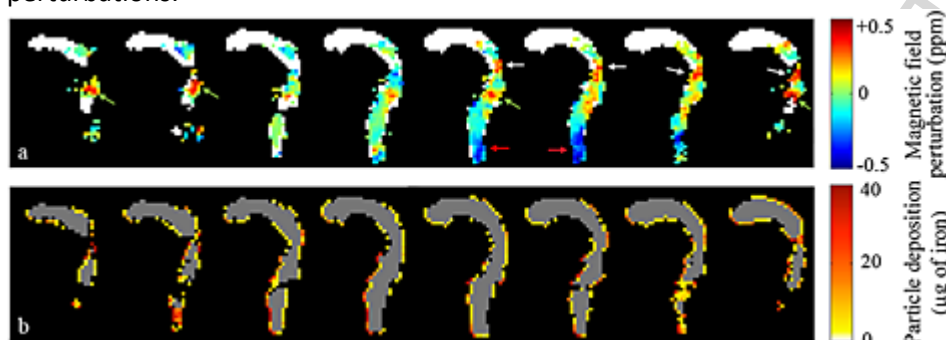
Phase-contrast helium-3 MRI of aerosol deposition in human airways. Reprinted from (Sarracanie et al., 2015) with permission of John Wiley and Sons.
